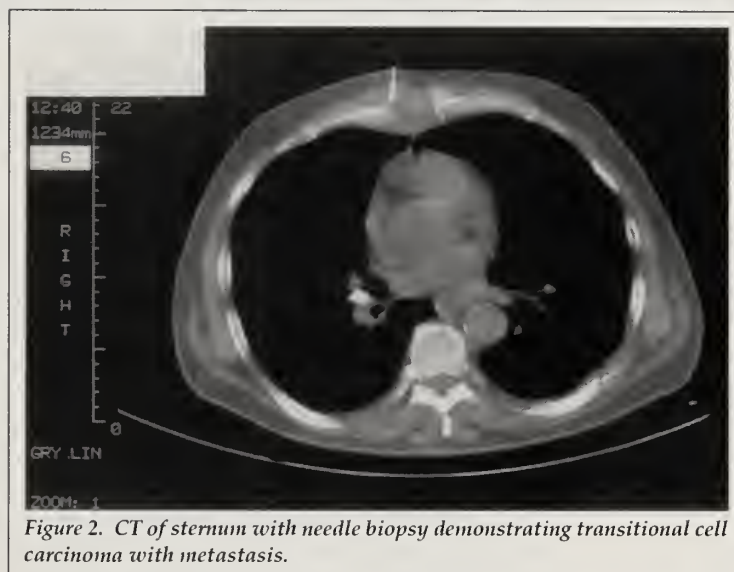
CT of sternum with needle biopsy demonstrating transitional cell carcinoma with metastasis.
